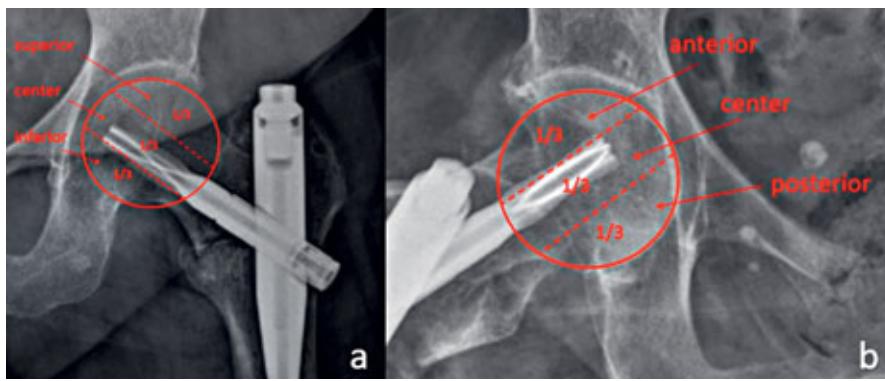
Determination of implant zones on antero-posterior (2a), and lateral radiographs (2b).
